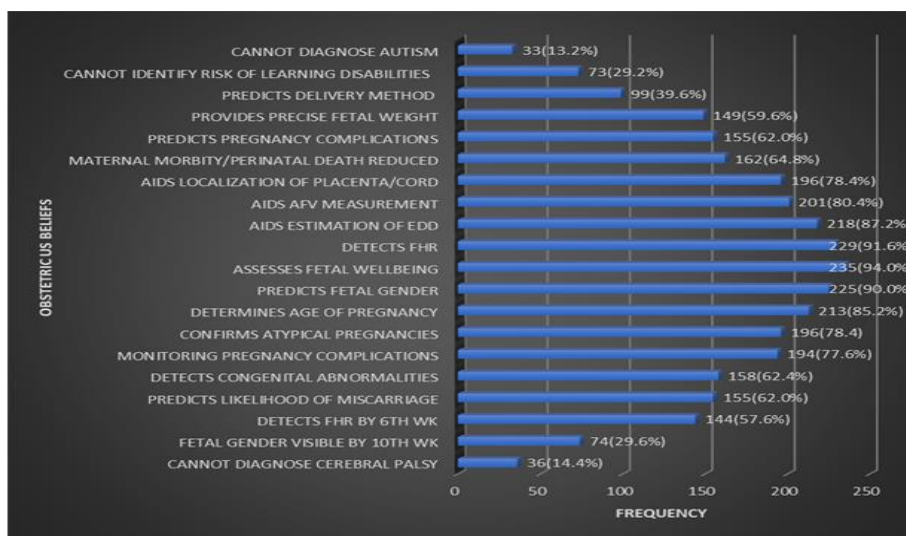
Distribution of beliefs statements towards obstetric ultrasonography at BSUTH
